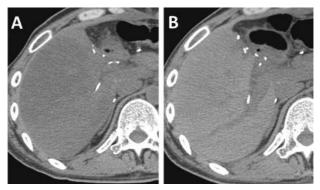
A Plain Computed Tomography Scan of the Grafted Liver Showed Severe Fatty Changes
